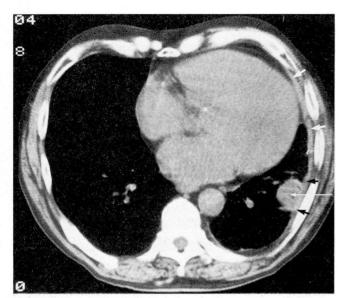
A 62-year-old man with a history of asbestos exposure. CT scan of the lower chest demonstrates bilateral calcified pleural thickening (black arrows). A curvilinear subpleural band of fibrosis, not demonstrated on the chest radiographs, is visualized in the right lower chest (white arrows).
